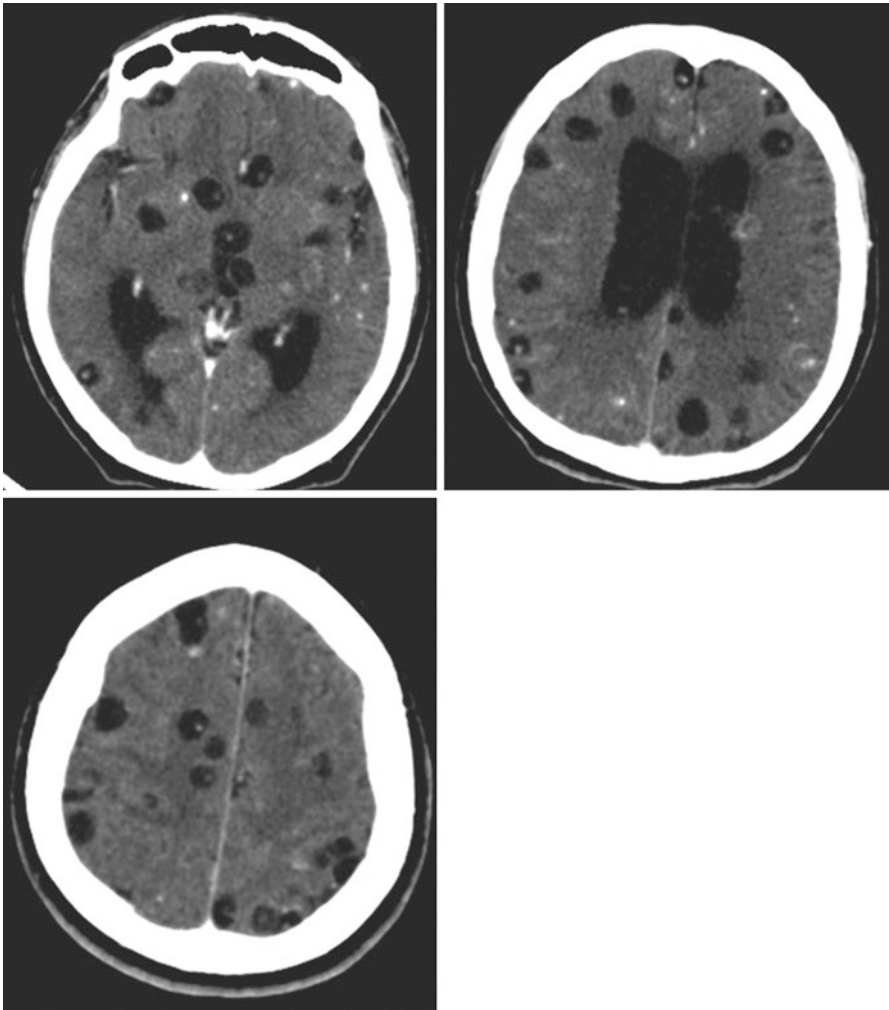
Contrast-enhanced CT of patient with heavy non-encephalitic cysticercosis. Cysts appear as well-defined hypodense lesions with no edema and no abnormal enhancement. The scolex can be visualized in the interior of some of these lesions as a brilliant dot
